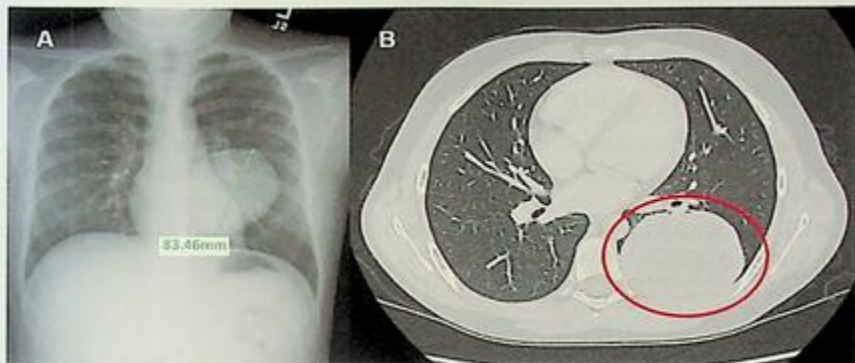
Chest X-ray results. Chest-X ray (A) and CT (B) of the chest wall mass lesion. The chest X-ray demonstrated a round, well-circumscribed mass measuring approximately 8.0cm in diameter at the posterior medial left lower lung (A). The chest CT also detected a 5.9 × 7.4 × 6.9cm left lower lobe mass posteromedially abutting the left posterior hilum (B).
